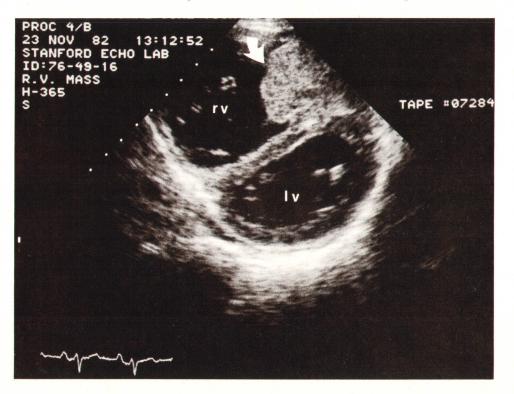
An echocardiographic image of the heart taken with the transducer on the chest wall in the parasternal position and oriented parallel to the short axis of the left ventricle (Iv). The arrow indicates an abnormal mass within the right ventricle (rv) attached to the interventricular septum. The mass has visual features that make it appear different from the myocardium (heart muscle). The mass is a malignant tumor from a distant site which has traveled to and grown in the heart. Note the echo-free (black) ventricular chambers compared to the low amplitude echoes within the myocardium and the tumor. Wall thickness can be judged from this image even in the absence of specular echoes from the blood-muscle interface.
